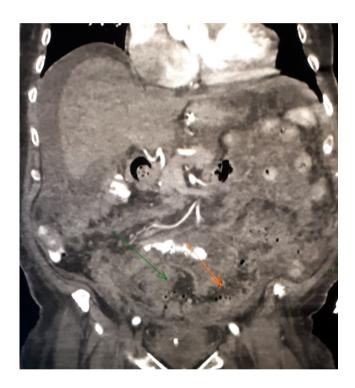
Abdominal computed tomography showing perihepatic ascites and mesenteric infiltration (irregular fat tissue—red arrow vs. healthy fat tissue—green arrow)
